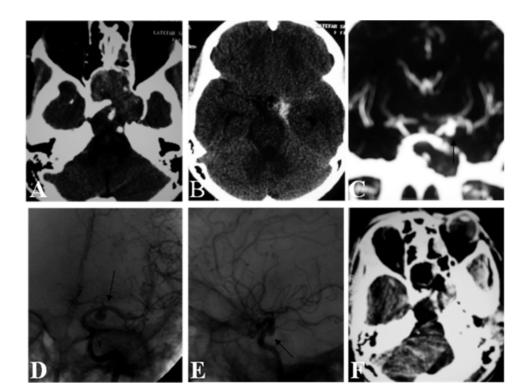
The axial CT image in (A) showed isolated sphenoid fungal sinusitis with left parasellar extension, (B) showed SAH in the left side of suprasellar cistern. (C) Reformated CTA image in the coronal plan showed left ICA bifurcation aneurysm. Four vessels angiography, A-P (D) and lateral (E) views confirmed the diagnosis of Left ICA bifurcation aneurysm. This patient was operated through right pterional approach for clipping of the aneurysm and for removal of the granuloma. (F) one month post-operative CT follow-up showed complete removal of the granuloma.
